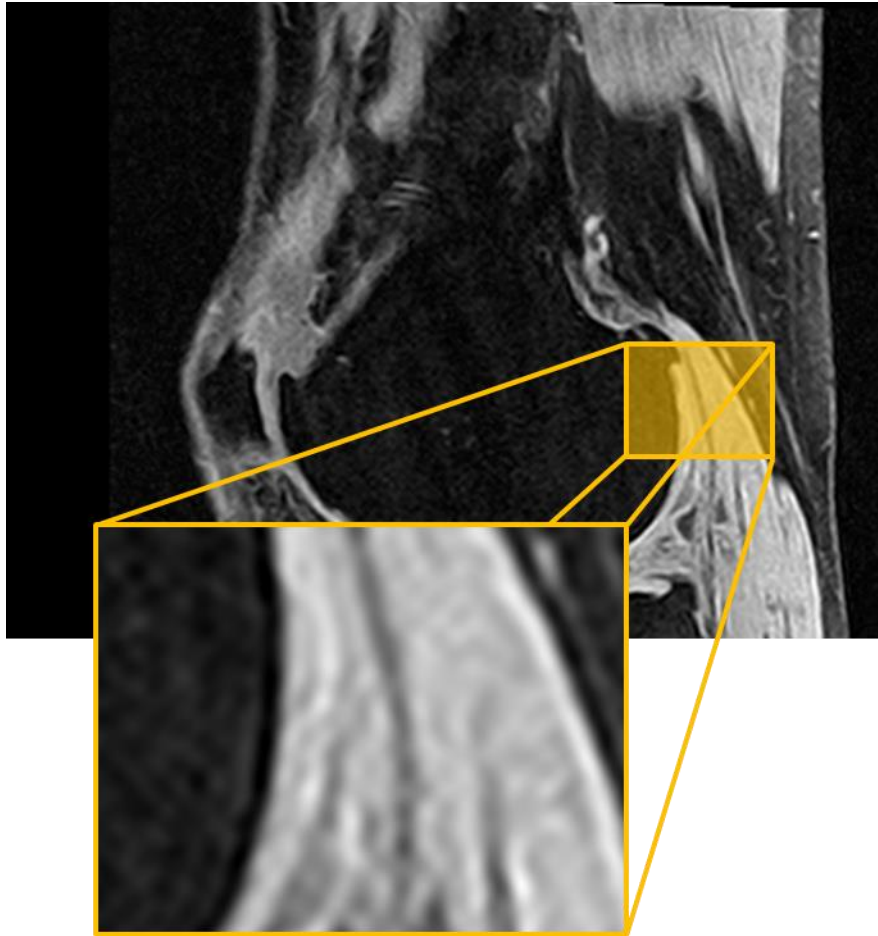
Cartilage as it appears in MRI. Notice the poor contrast in contact areas, as well as the thin-sheet appearance of the tissue – sometimes only a few pixels in width.*
